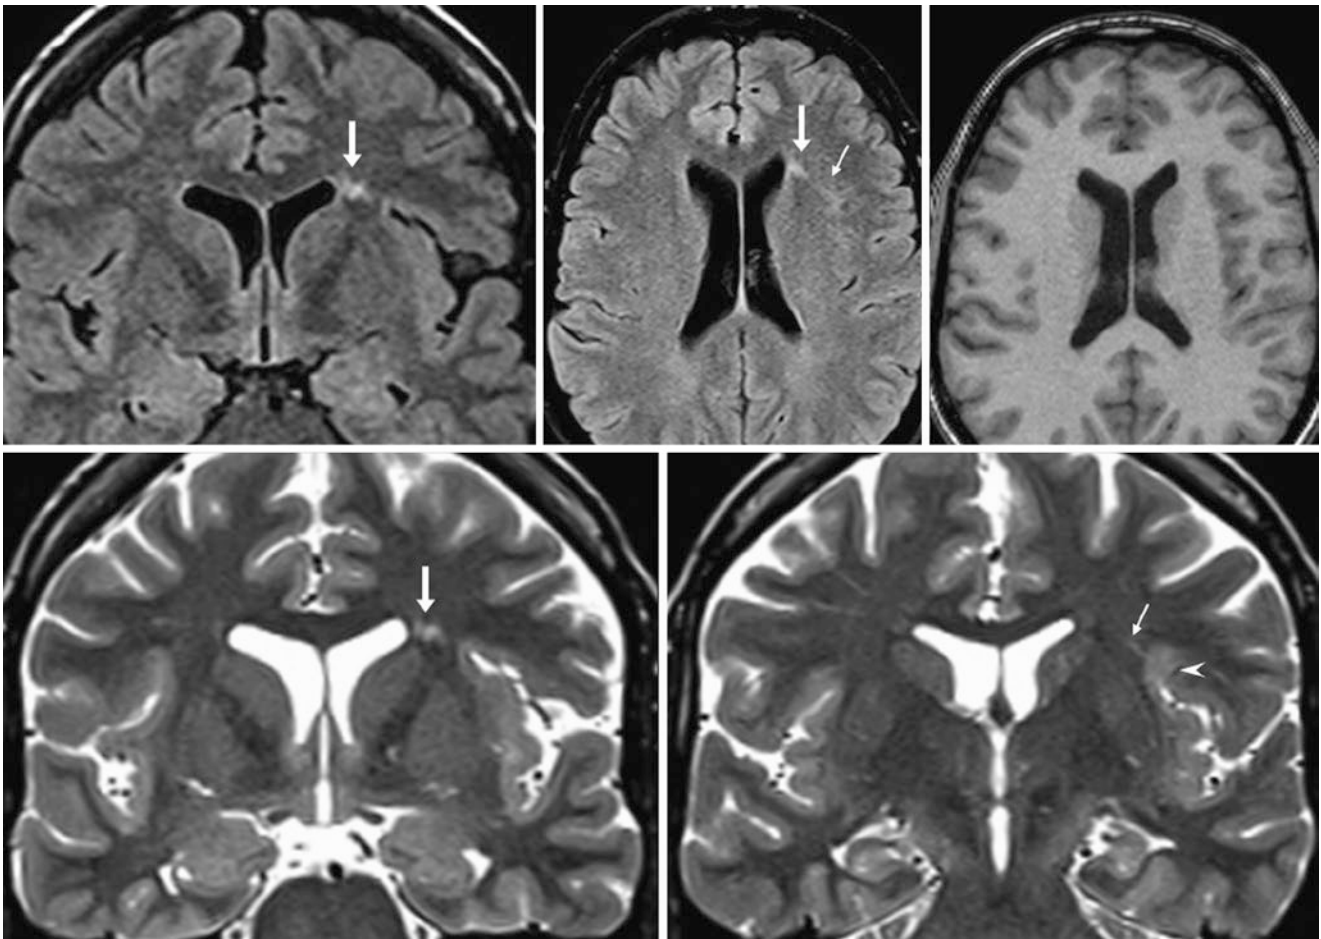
Comparison case of focal cortical dysplasia. In a 34 year old with seizures, a 1.5 T MRI demonstrated focal periependymal signal (*arrows*) on coronal FLAIR (*top left*), with a radiating, tangential band on axial FLAIR (*top middle*). An axial T1WI (*top right*) appeared
